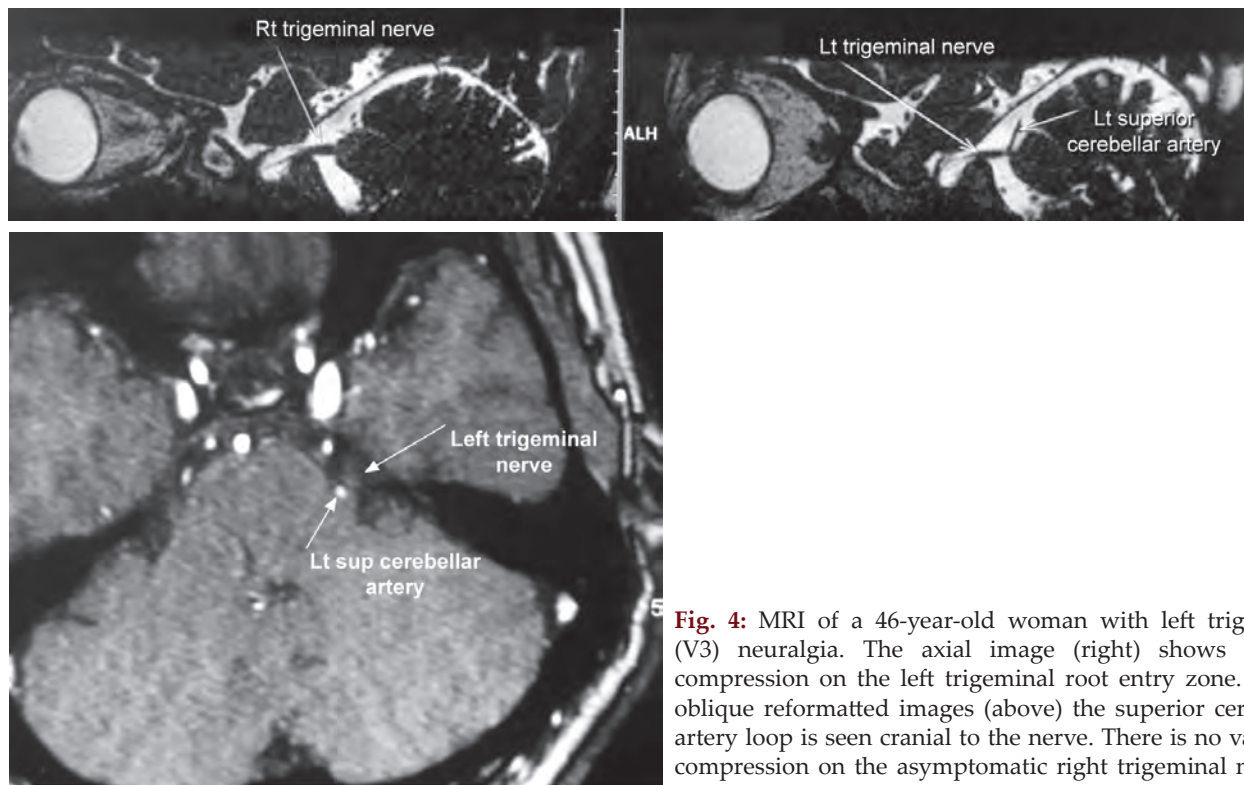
MRI of a 46-year-old woman with left trigeminal (V3) neuralgia. The axial image (right) shows medial compression on the left trigeminal root entry zone. In the oblique reformatted images (above) the superior cerebellar artery loop is seen cranial to the nerve. There is no vascular compression on the asymptomatic right trigeminal nerve
